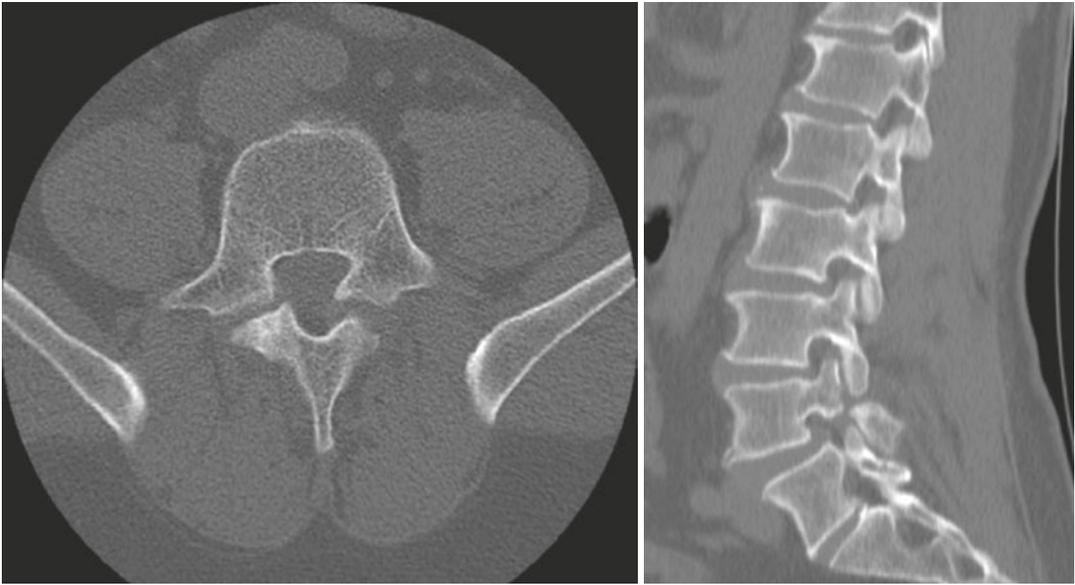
L5 spondylolysis on axial (left) and sagittal (right) CT scan images
